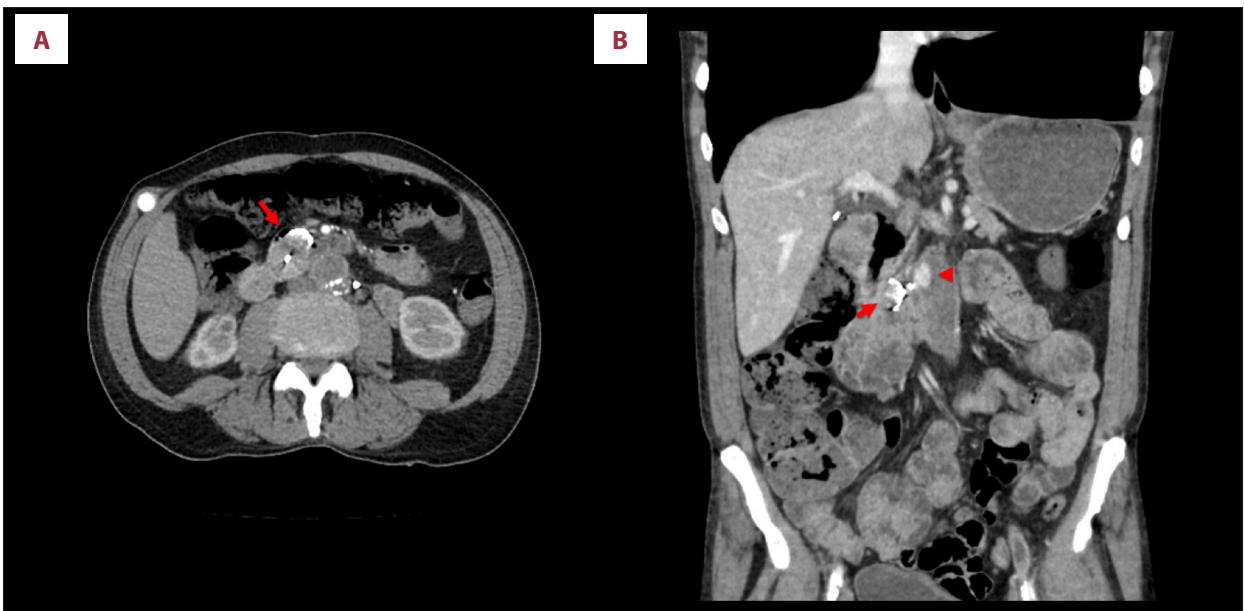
(A) Abdominal axial computed tomography (CT) scan with intravenous contrast demonstrating air and extravasated contrast in the duodenum (arrow). (B) Abdominal coronal CT scan with intravenous contrast in the duodenum (arrow) and in the thrombosed aortoiliac bypass graft (arrowhead). Note the loss of fat plane between the thrombosed graft and the adjacent duodenum.
